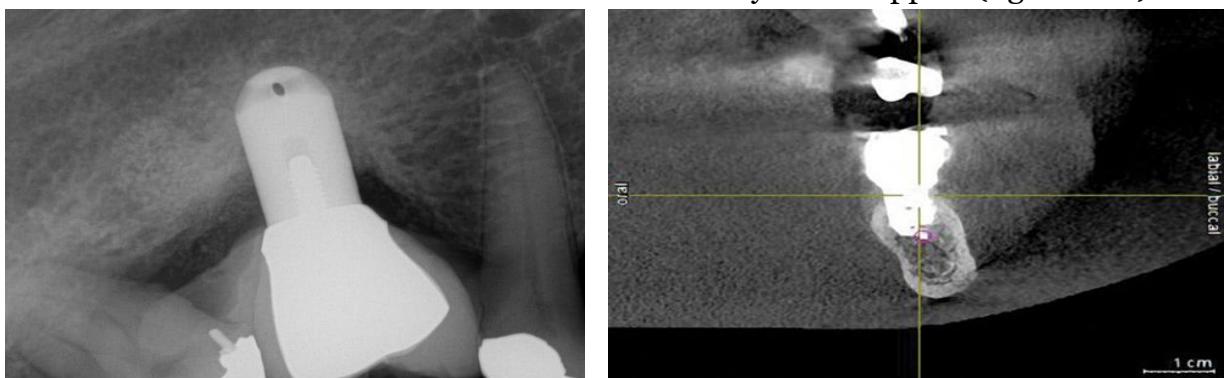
The Implant was installed in tooth area 30. After the anesthesia effect ended, the patient began to complain of the presence of paresthesia in the area of the right lip and chin. An X-ray taken immediately after implantation shows no signs of penetration of the implant into the lower nerve canal.
